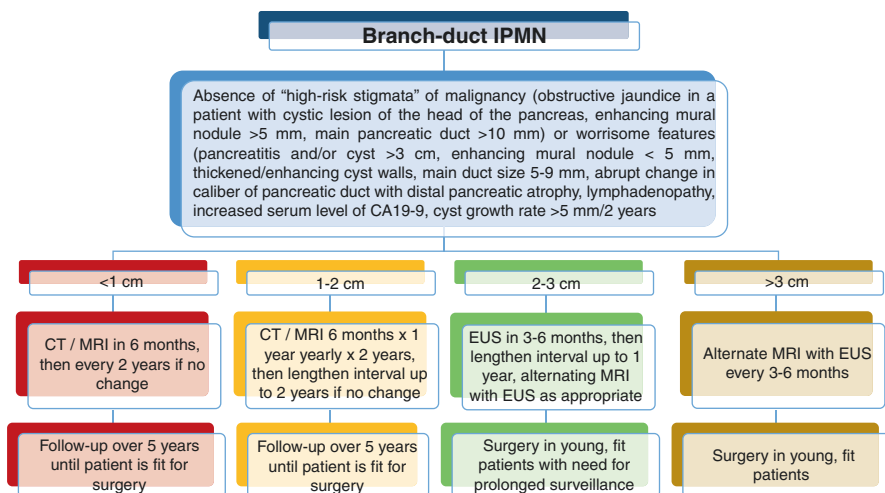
Management of branch-duct intraductal papillary mucinous neoplasms (IPMNs). *CT* computed tomographic scan, *MRI* magnetic resonance imaging, *EUS* endoscopic ultrasonography, *CA 19-9* Carbohydrate Antigen 19-9
